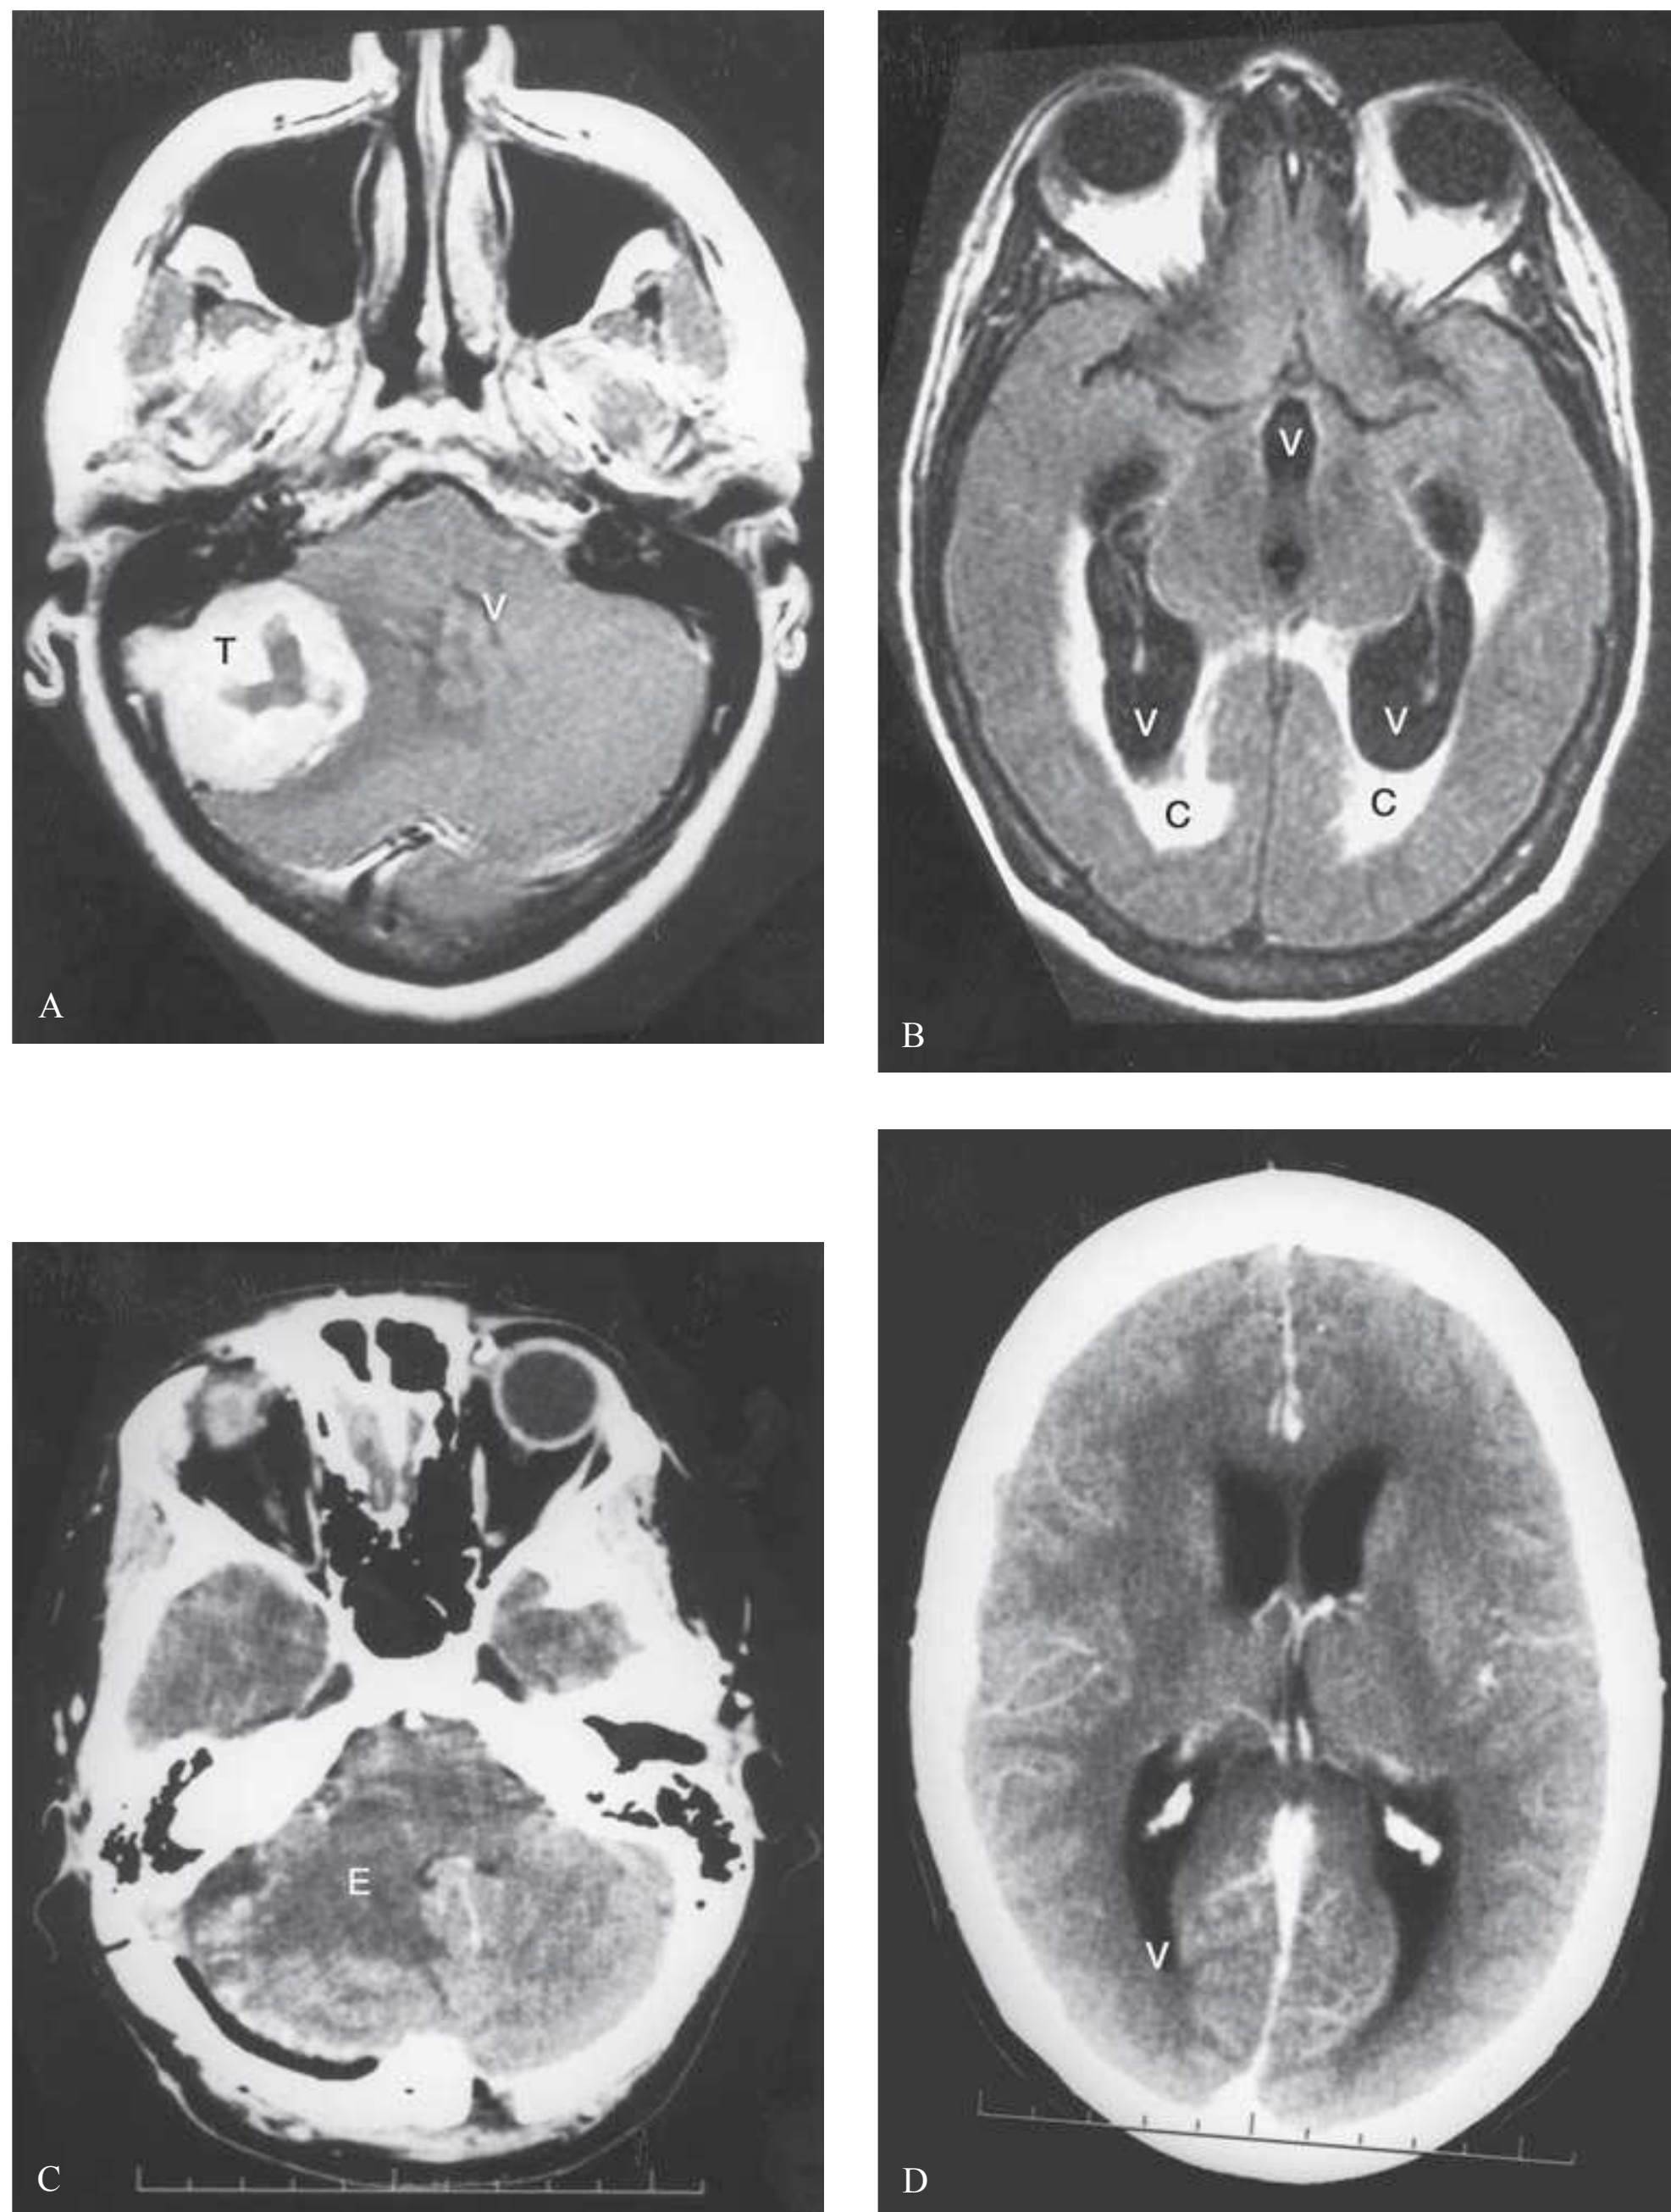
A: This magnetic resonance imaging (MRI), performed on a patient presenting with headache and obtundation, shows an enhancing mass in the right cerebellopontine angle (T) with displacement of the fourth ventricle (V) to the left. B: Additional views of the MRI show hydrocephalus, with enlarged, rounded ventricles (V) and transependymal spread of cerebrospinal fluid (CSF) (C). A ventriculostomy to drain CSF was placed to temporize the patient prior to surgery. C: After resection of the tumor, a meningioma, the fourth ventricle, returns toward its normal position. Edema (E) in the cerebellar hemisphere is still present. D: Hydrocephalus has resolved, with the ventricle (V) returning to normal size and shape.
